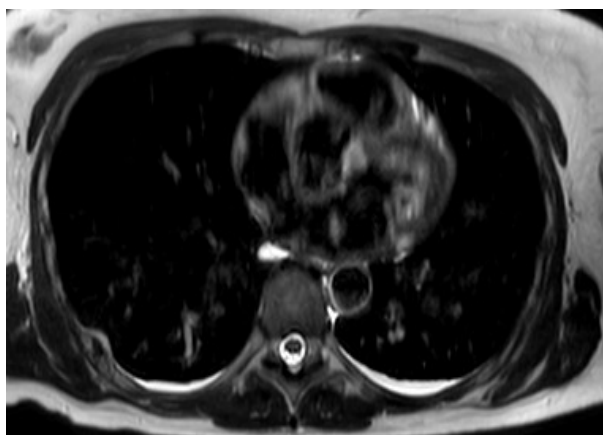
Chest MRI T2 without contrast: the lesion is radiologically nonspecific for hemangioma.
